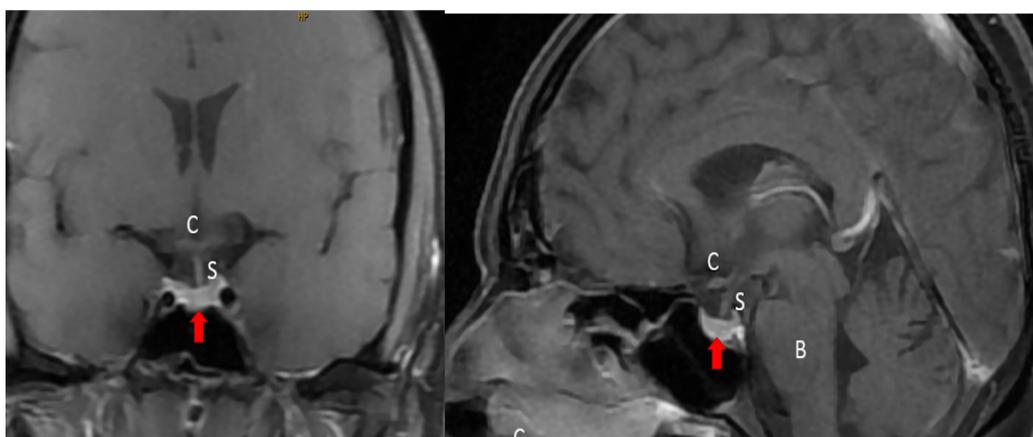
The patient, a 36-year-old female, underwent imaging of the pituitary fossa using sagittal and coronal T1-weighted post-contrast techniques. The imaging revealed the presence of enhancing pituitary tissue (indicated by a red arrow) within the Sella, along with the posterior pituitary bright spot (indicated by a yellow arrowhead) located behind it. Other notable structures observed in the imaging include the optic chiasm, denoted by C, the pituitary stalk indicated by S, and the brainstem, indicated by B.
